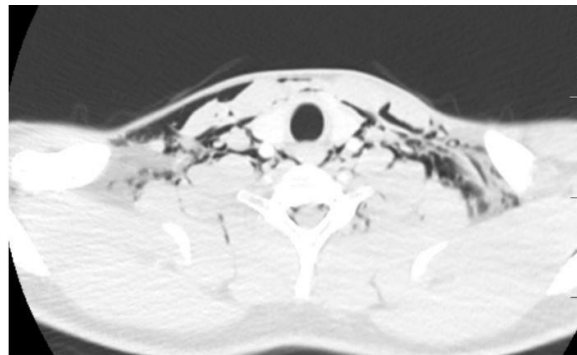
(Thoracic Computed Tomography): The thoracic computed tomography (CT) scan also demonstrated air collections extending into the muscle planes, with subcutaneous emphysema visible from the cervical to the thoracic regions.
